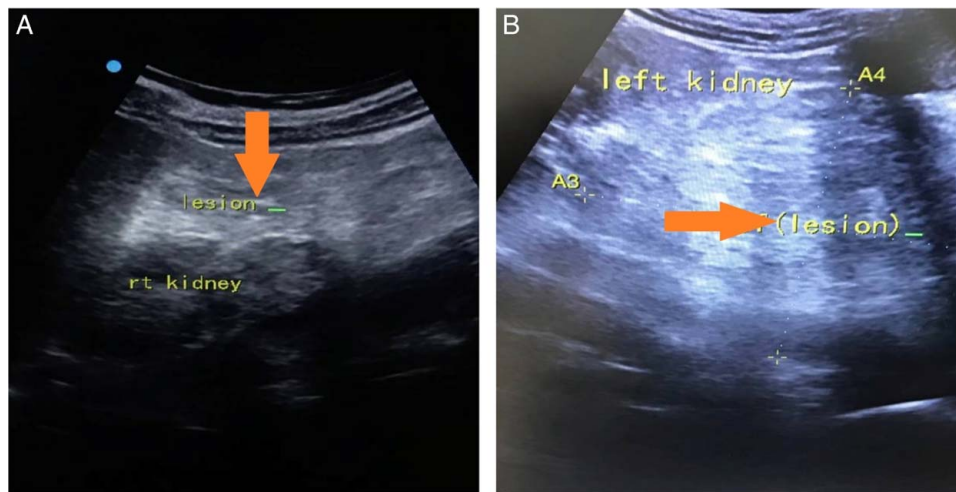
Ultrasound of the right kidney (A) and left kidney (B) shows echogenic mass lesions/angiomyolipomas bilaterally (red arrows in A and B).
